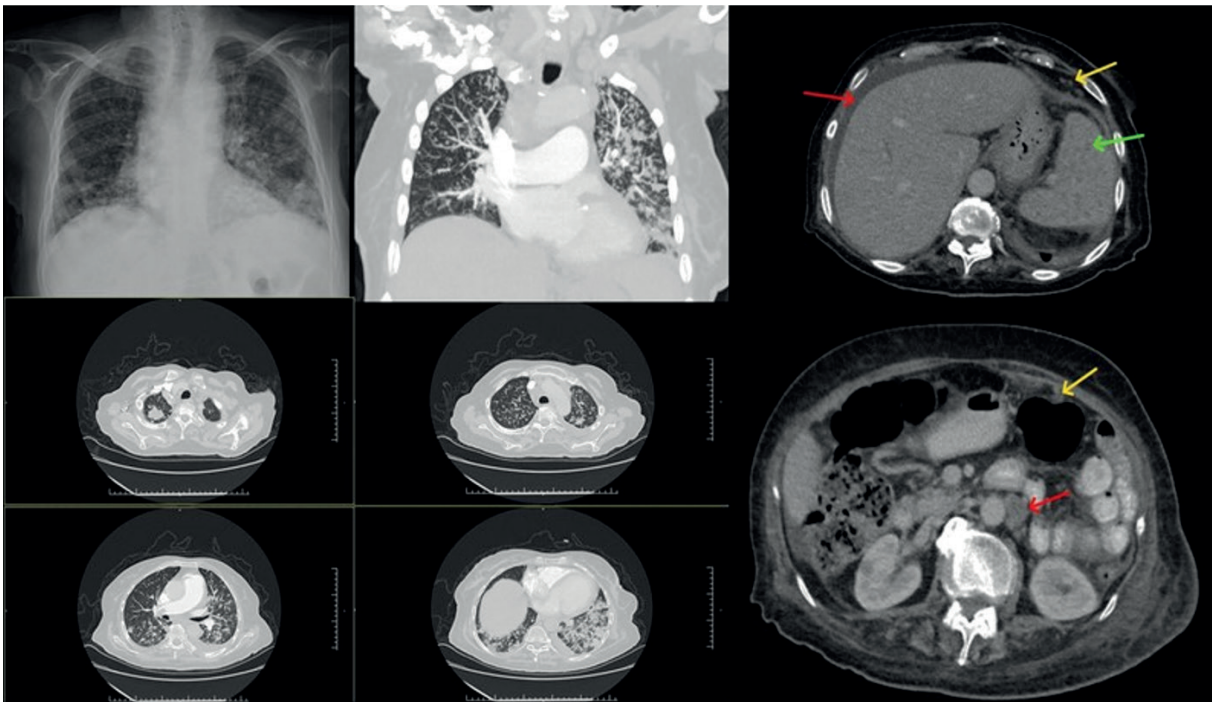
Diffuse nodular and infiltrative lesions on the thorax CT, paraaortic LAP, ascites, pulmonary embolism, and multiple lesions in the spleen.
